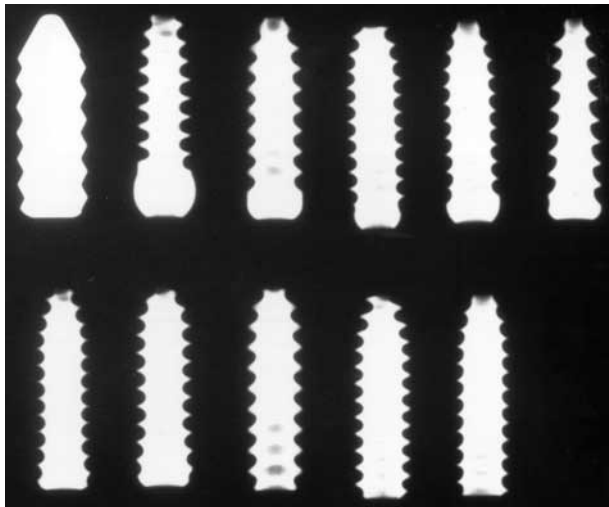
The screws in Fig 1 are shown radiographically in the same sequence. Note the 100-mm radiographic reference rule. Note the round-head, tapered-head, and flat-head variations.
